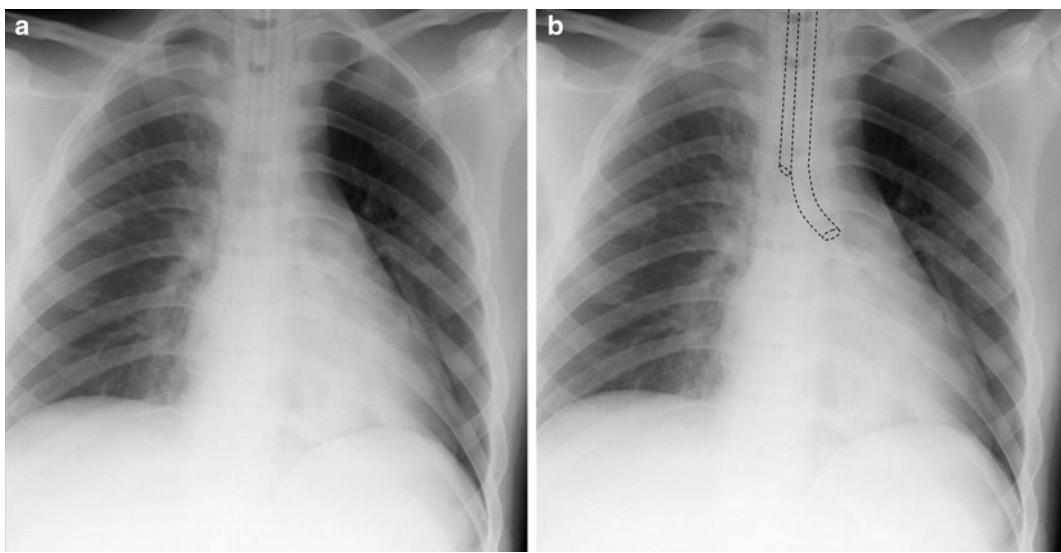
(a) The chest radiograph of a patient with a left-sided DLT in place. Notice the endobronchial lumen is approximately 2 cm below the tracheal carina into the left mainstem bronchus. (b) A reconstruction of the DLT which is marked in the chest radiograph.
